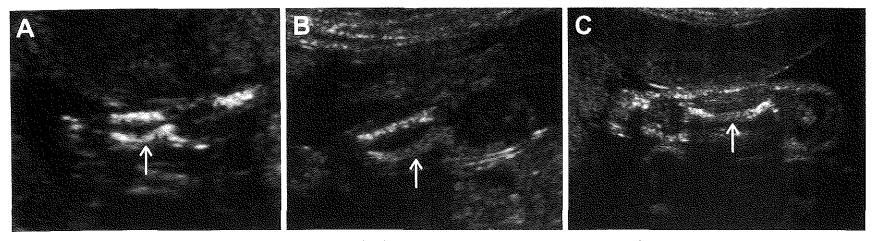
Ultrasound images of the second affected fetus showing bowing and broad ends of the tibia (arrows) at 16 (A), 20 (B) and 28 (C) weeks of gestation.
